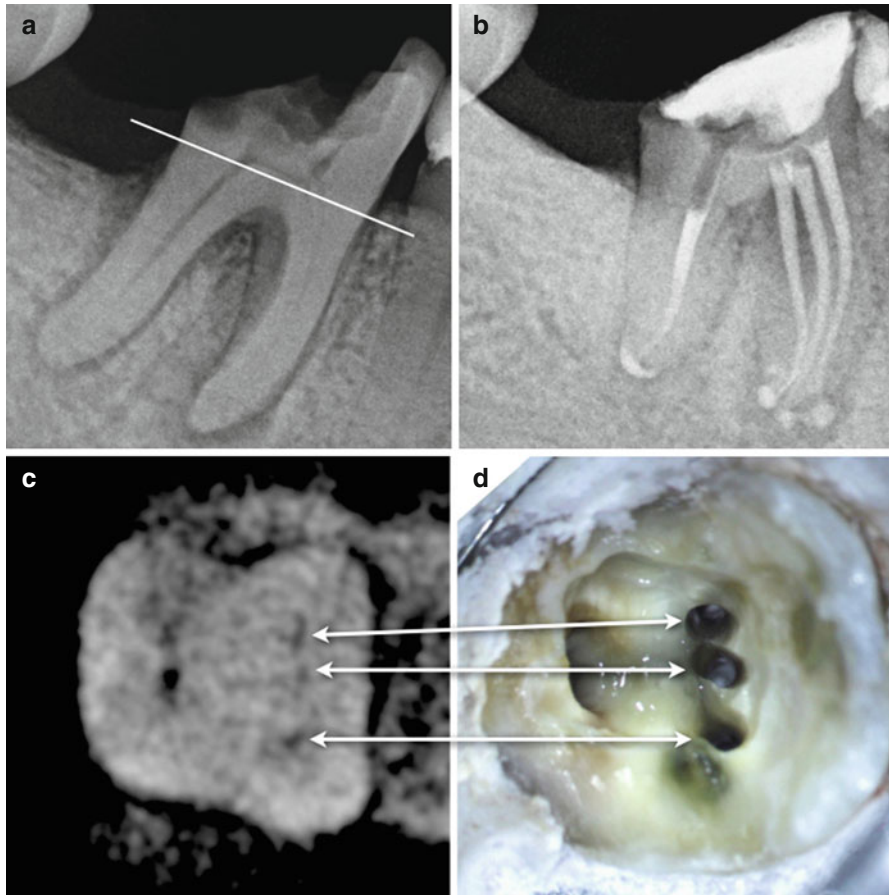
Preoperative periapical radiograph of a mandibular right first molar (*white line* represents level of the axial CBCT slice [below]) (a). Postoperative periapical radiograph demonstrating three mesial canals with separate apical foramina (b). Axial CBCT slice demonstrating three identifiable mesial canals (c). Clinical photo demonstrating three instrumented mesial canals in the exact location shown in the preoperative axial CBCT slice (*arrows*) (d)
